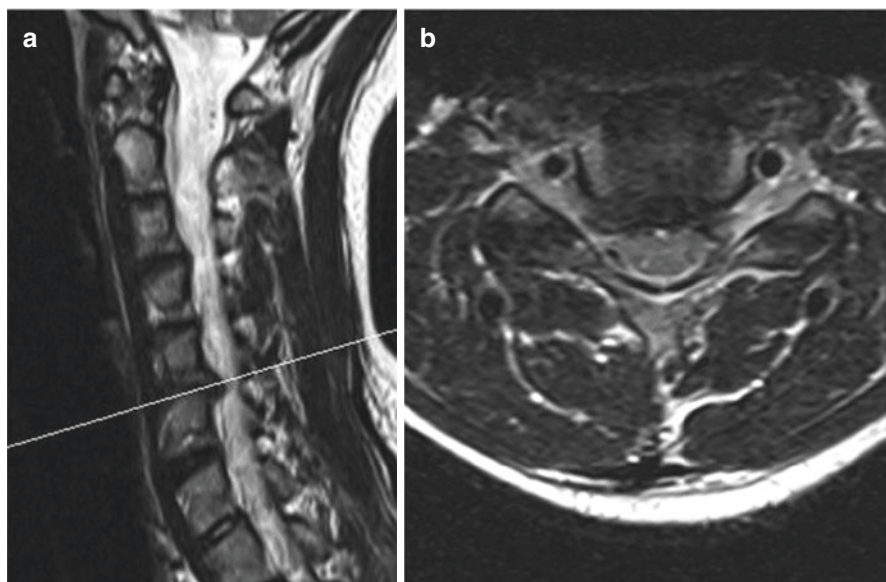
Right lateralized Cervical 5–6 herniated disk. (a) Preoperative MRI cervical spine T2 sagittal shows a herniated disk at the C5–6 level lateralized to the right causing radiculopathy. (b) MRI cervical spine T2 axial shows right sided foraminal stenosis with nerve root compression secondary to disk herniation at the C5–6 neural foramen
